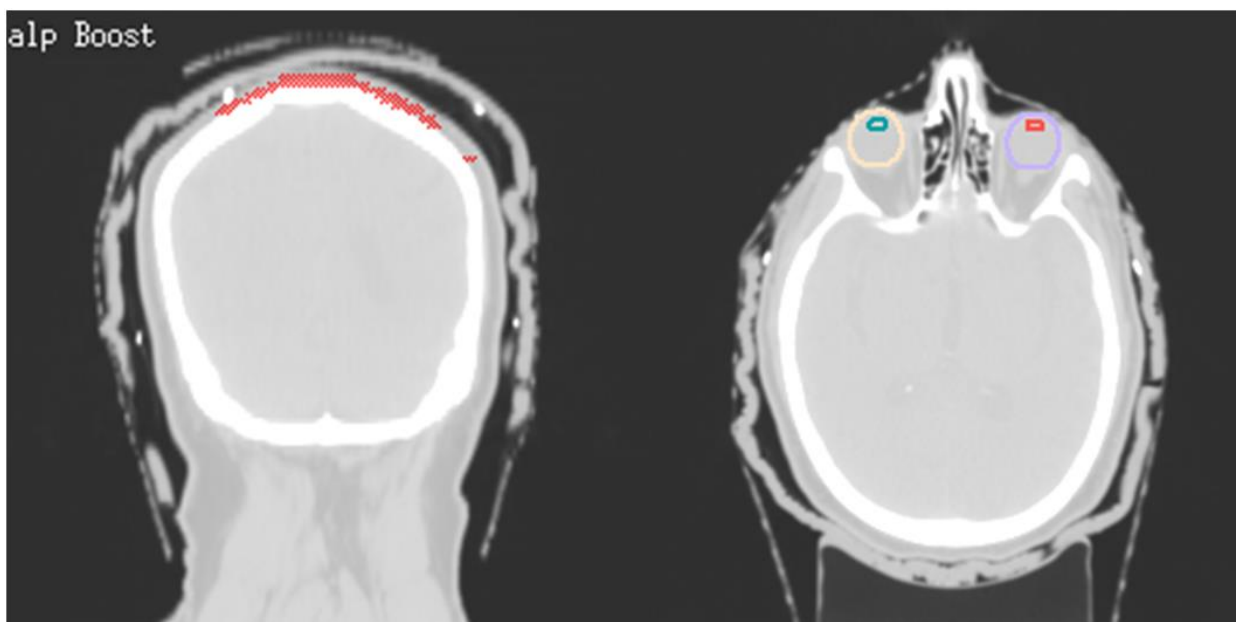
CT slices showing the air gaps that can form between the bolus and the scalp with the MD Anderson scalp bolus technique
